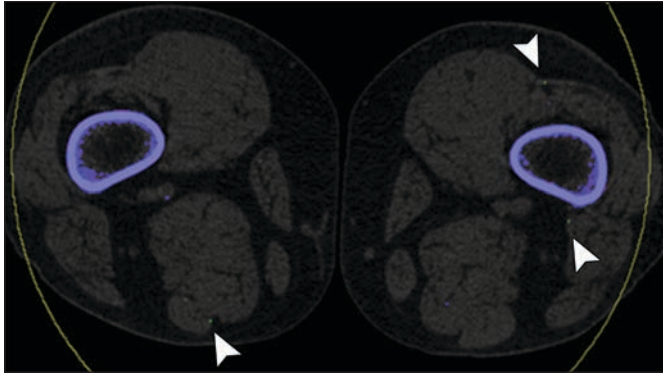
Submillimeter artifact (*arrowheads*) is seen on axial dual-energy CT (DECT) image of thighs of 67-year-old woman.
